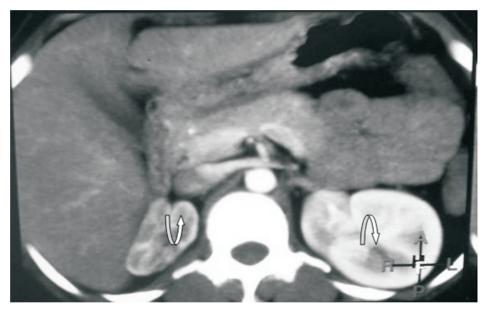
Axial contrast enhanced CT image of the upper abdomen, showing enhancing but shrunken right kidney (curved arrow up) and normal left kidney (curved arrow down).
